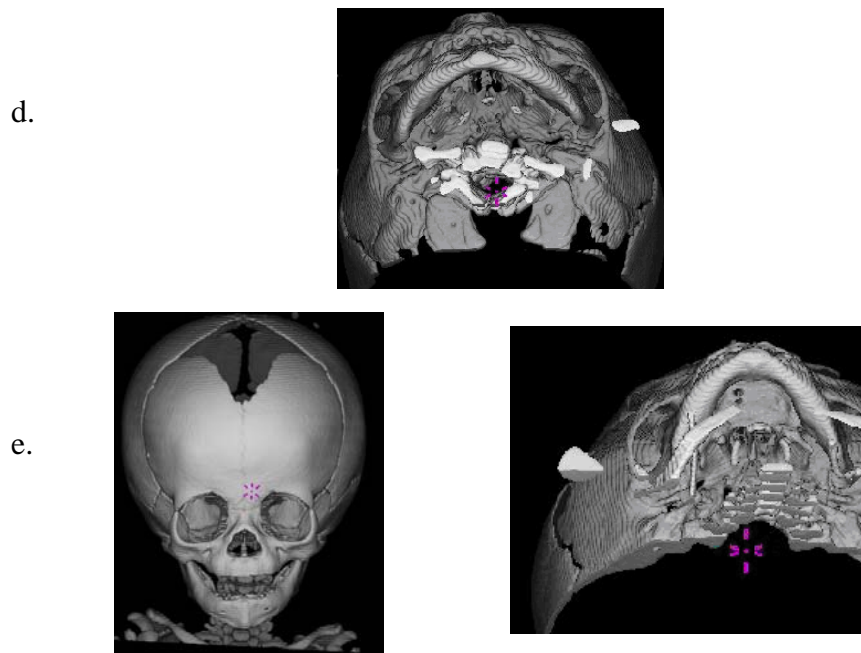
3D CT reconstructions of: (a) UCLP (b) CL (c) BCLP (d) ICP and (e) NC.
